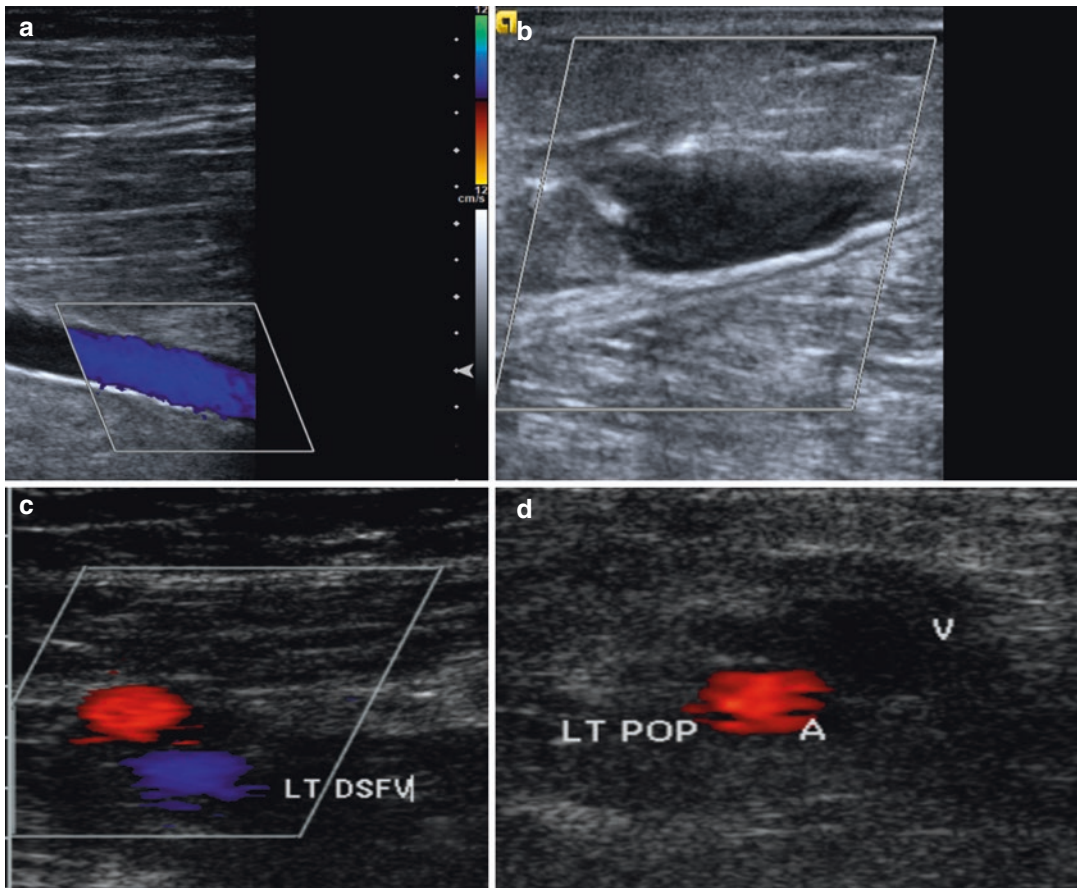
Color Doppler imaging showing (a) color flow in the lumen, (b) absence of color flow in the lumen suggesting a clot, (c) an example of venous and arterial
